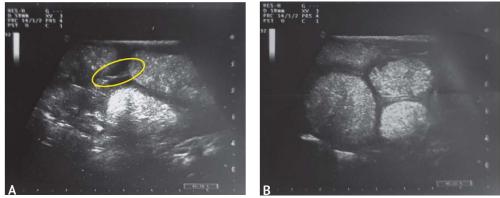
Transabdominal ultrasound examination: A - an echogenic band was identified between the loops of the small intestine (cord-like adhesion); B - dilated loops of the small intestine (transverse scan)
